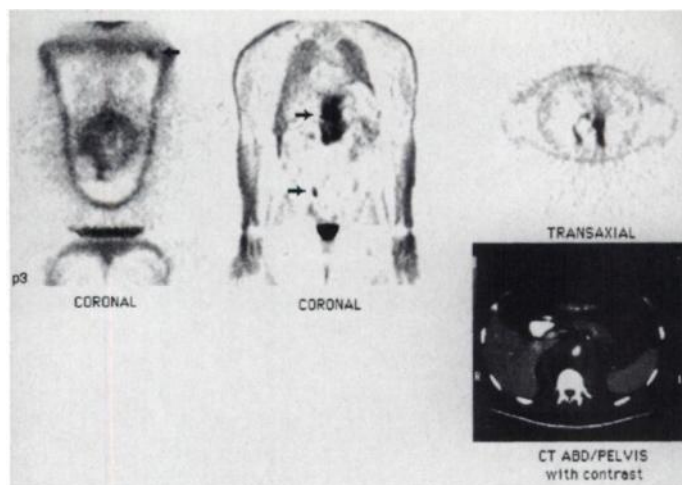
Coronal (p18), transaxial (p3, bed6) whole-body FDG images demonstrate a large complex mass in the upper abdomen with areas of hypermetabolism and ametabolism (necrosis) that correlate with the mass seen on the CT scan of the abdomen/pelvis. The coronal image shows a more accessible left axillary nodal focus where subsequent biopsy revealed a diagnosis of Burkitt's lymphoma.
